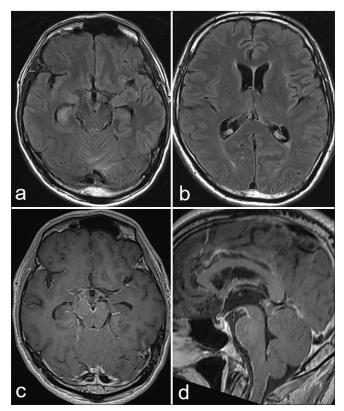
(a and b) Axial images of the brain magnetic resonance imaging in Fluid attenuated inversion recovery (FLAIR) show hyperintense changes of the bilateral mesial temporal lobe and periventricular area surrounding both frontal horns of lateral ventricles, as well as choroid plexus. (c and d) Postcontrast leptomeningeal enhancement and thickening of meninges involving the brainstem can be seen.
